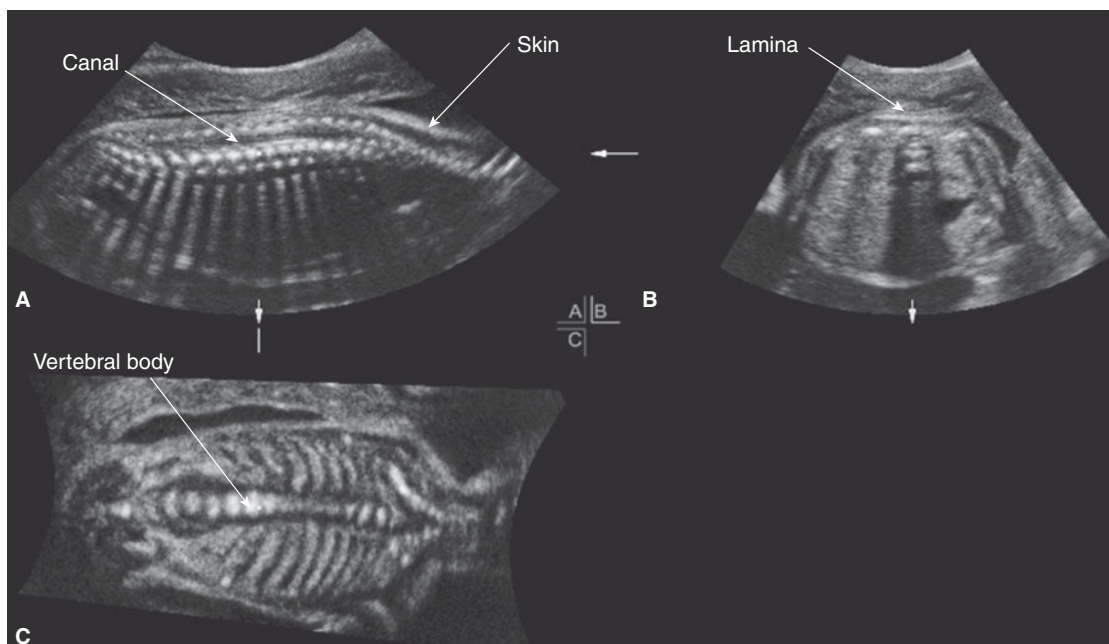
Using 3D sonography, the spine is displayed along three orthogonal scanning planes: sagittal (A), transverse (B), and coronal (C).
